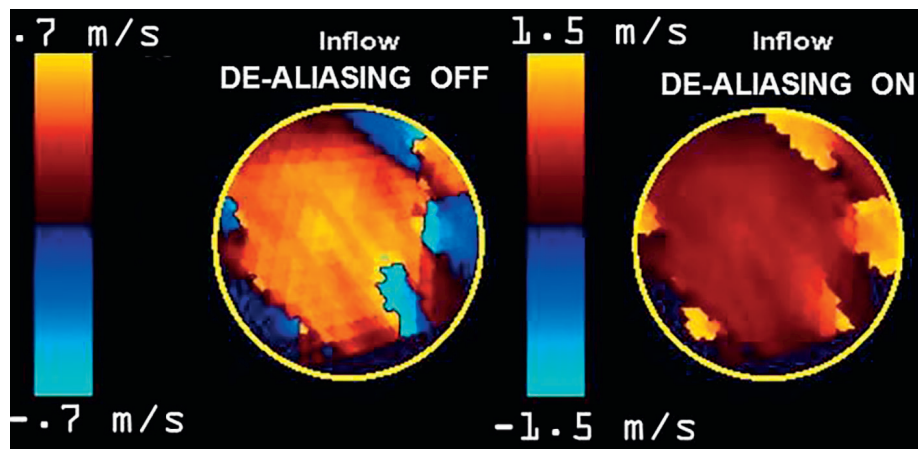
Example of volume color Doppler with tracked disc. The results are used to construct the cross-sectional color flow data. The area under the curve is used to calculate the inflow and outflow stroke volume.
